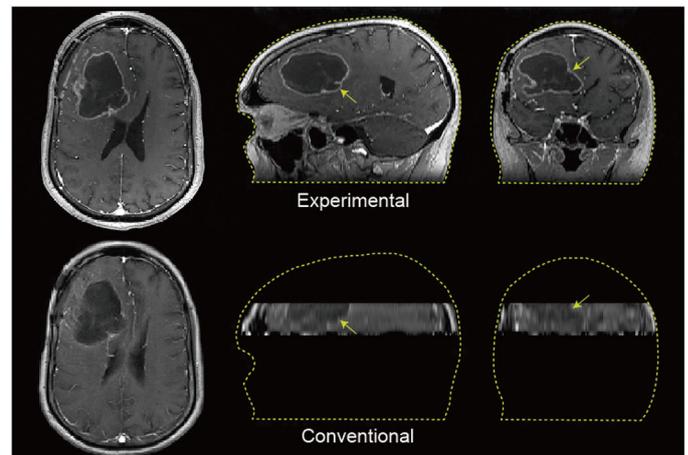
Spatial coverage of the experimental and conventional brain dynamic contrast-enhanced (DCE) MRI scans. The experimental scan provides high nearly isotropic spatial resolution over the entire brain, and allows for arbitrary reformatting. This patient had a large 6cm glioblastoma multiforme that was completely captured by the experimental scan.
